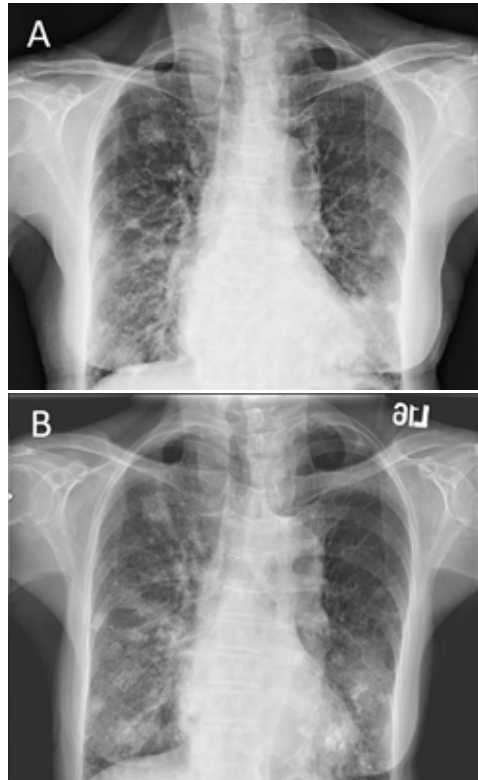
(A) Chest radiography revealed bilateral lung nodules 2 years before this visit; (B) Follow-up chest radiography while in admission revealed bilateral lung nodules with calcification. The size of the lung nodules enlarged slowly.
